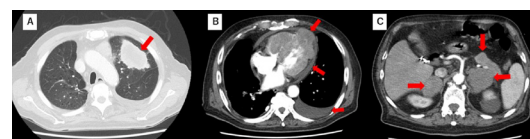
(A) Chest CT showing emphysematous changes and a mass (6 cm in length) in the left upper lobe of the lung (arrow). (B) Irregular myocardial wall thickening with heterogeneous contrast effect, pericardial effusion and left sided pleural effusion are shown (arrows). (C) Abdominal CT showing masses in the pancreatic tail and bilateral adrenal glands (arrows).
